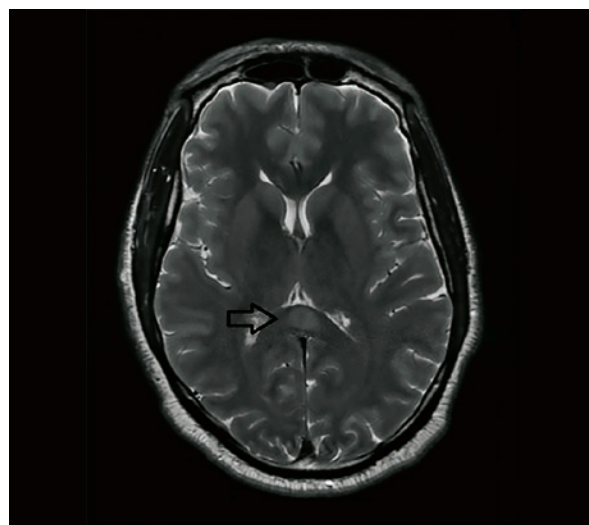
MRI, T2 WI, axial view of brain, display of hyperintense signal localized in the splenium of the corpus callosum.
